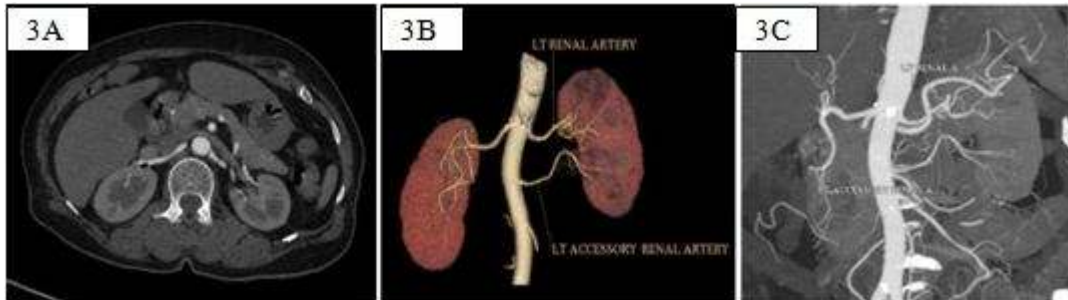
CT renal angiogram done in 120 kV with axial source image (3A), Volume rendered image (3B) and Maximum intensity projection in coronal view (3C).
